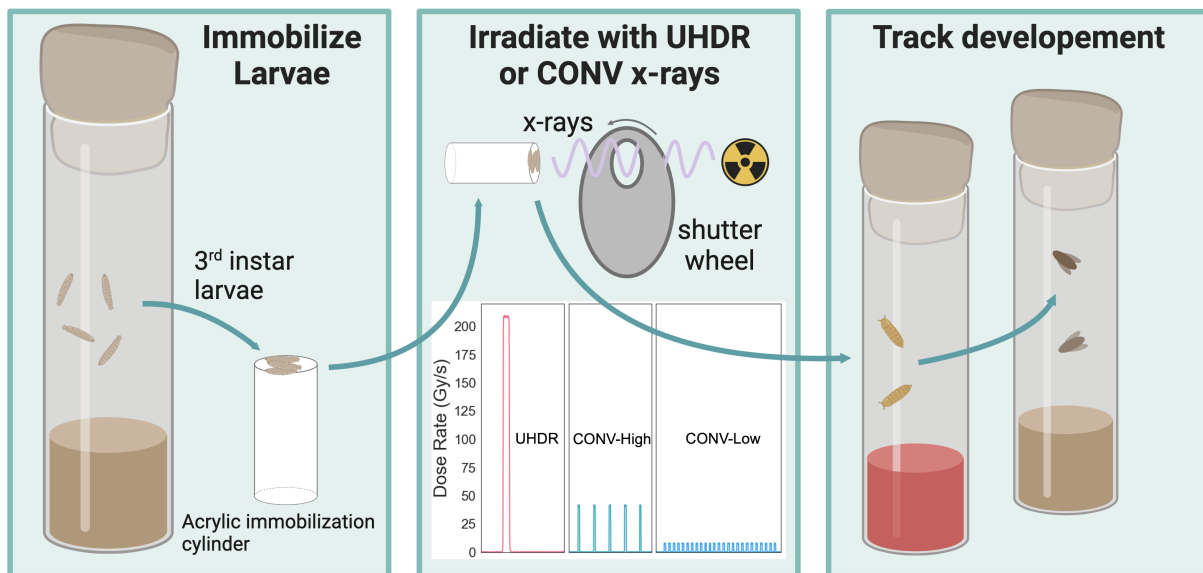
Procedure for immobilizing and irradiating third instar larvae *D. melanogaster* within the x-ray tube shutter system. The UHDR and CONV delivery schemes are shown in the second panel.
